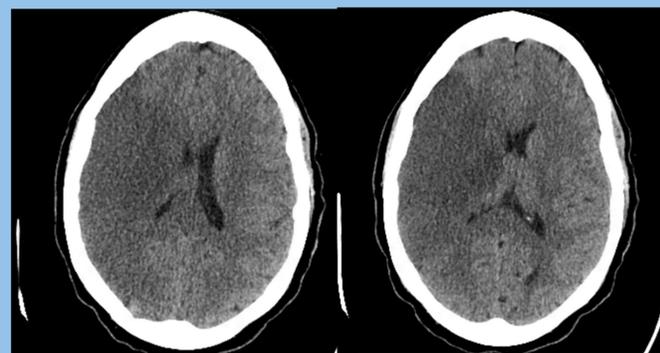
Computed Tomographic image of right middle cerebral artery territory infarct
